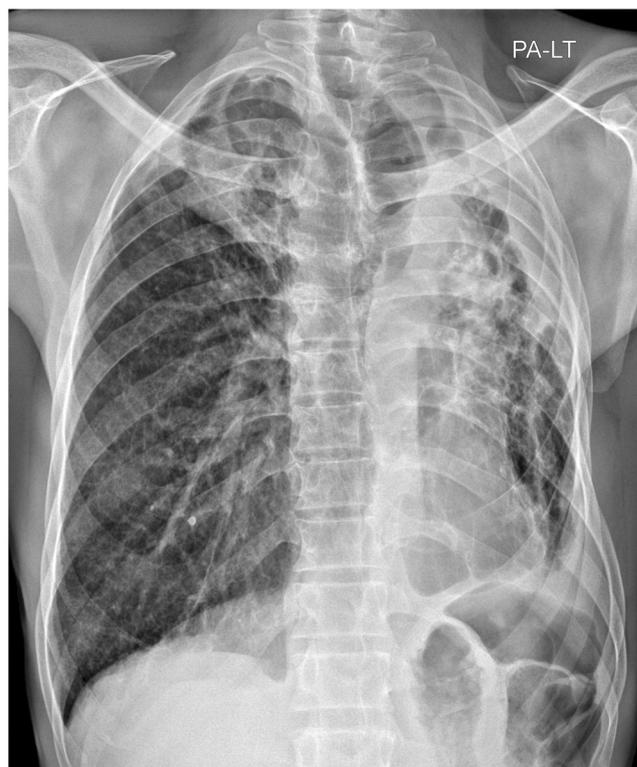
Chest X-ray (from 2017) of a 61 year-old ex-gold miner with 21 years of underground gold mining, HIV positive, and on his fifth episode of treatment for TB.
